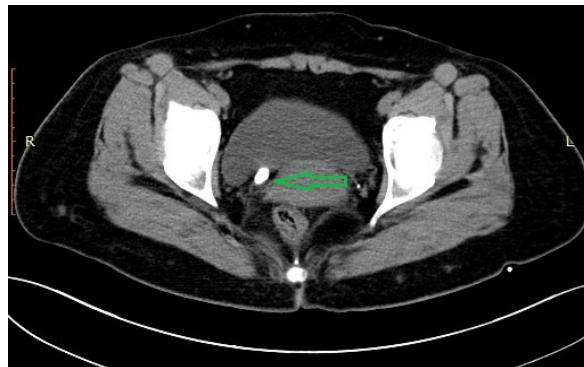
CT KUB showing right lower ureteric calculus.
